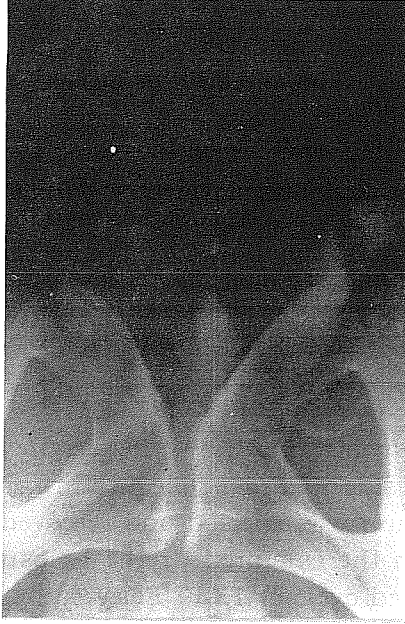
1. Appearance of the calculus on plain film.
